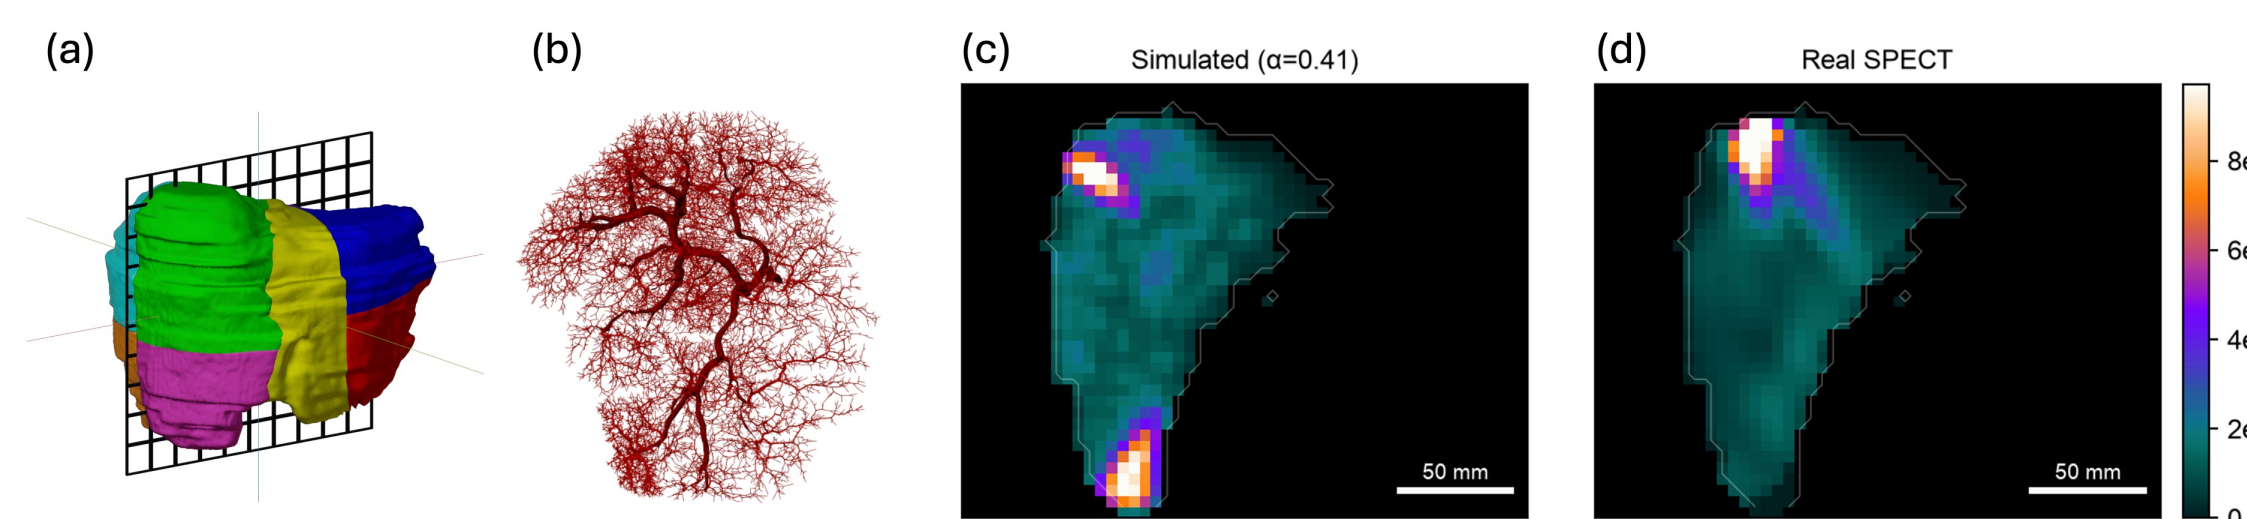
Calibration. Synthetic [^{99m}Tc]Tc-MAA activity at the fitted $\alpha=0.41$ vs. the patient's clinical SPECT (same colour scale); 3-D gamma pass rate 78.5%.
